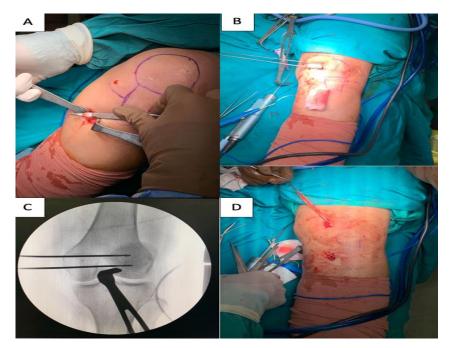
Approach of MPFL reconstruction using gracilis tendon autograft (A) detach the gracilis tendon, (B) K-wire parallel configuration, surgeon marked the drill site of the patella, (C) radiograph to determine the tunnel site, and (D) graft was passed through the medial femoral insertion.
